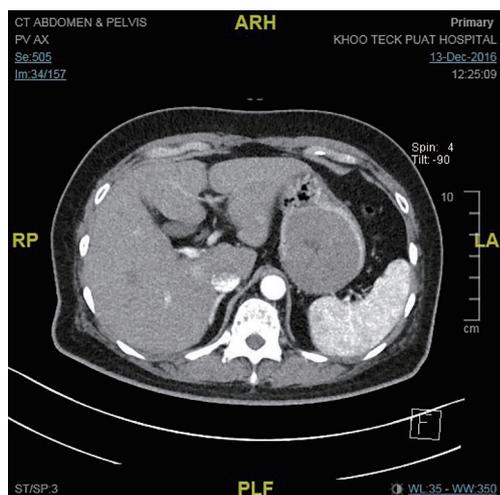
CT scan of the abdomen and pelvis showing a dominant exophytic gastric GIST. CT, computed tomography; GIST, gastrointestinal stromal tumor.
